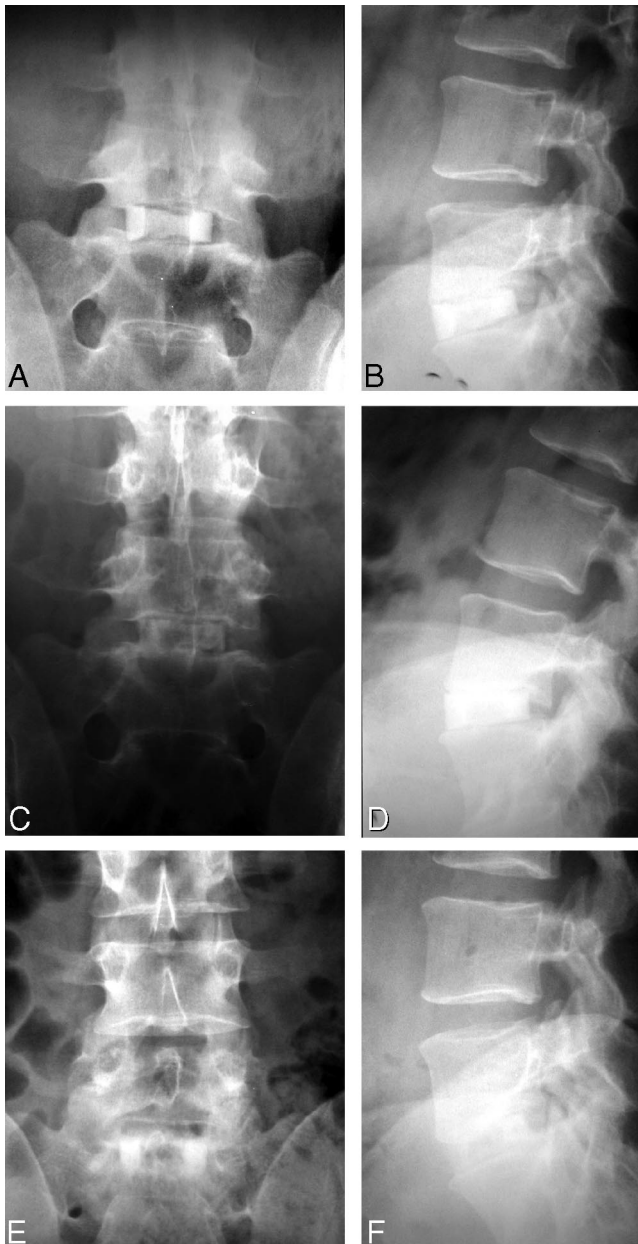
Sequential radiographs of ALIF with FRA and rhBMP-2 at various stages after surgery: immediate postoperative (A, B), 3 months (C, D), and 6 months (E, F). Note earlier initiation of trabecular continuity compared to autogenous ICBG use (Figure 2).
